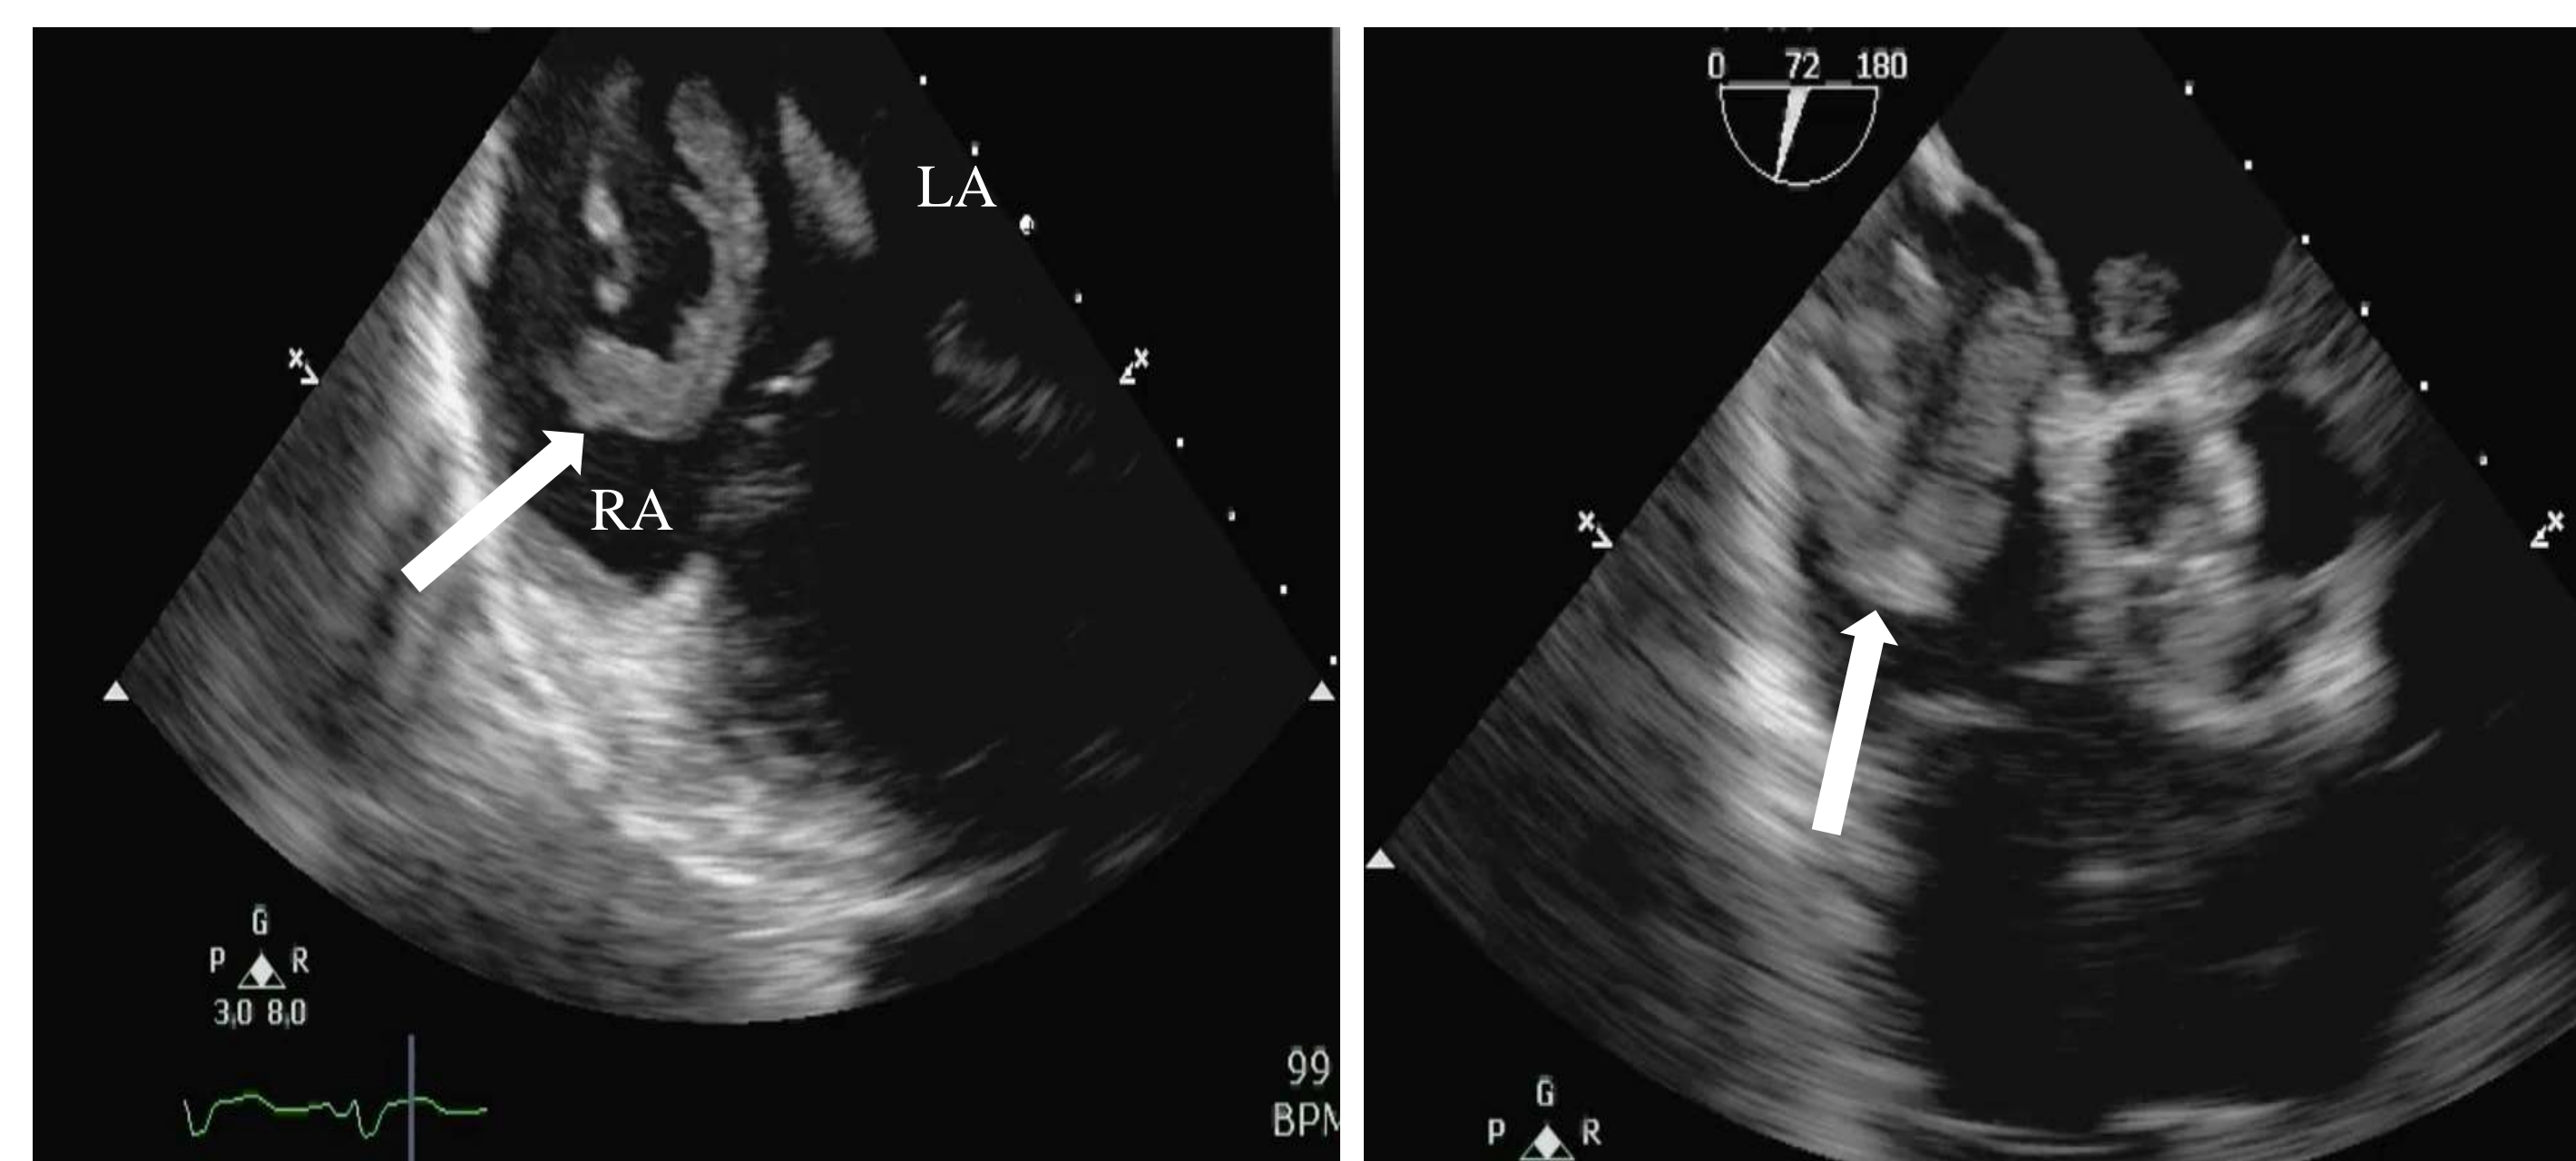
Transesophageal echocardiogram view of the interatrial septum. White arrow in both images is pointing a echogenic structure (thrombus) in the right atrium RA straddling through the patent foramen ovale PFO in the left atrium LA. Similar echogenic structure seen in the mitral valve.
